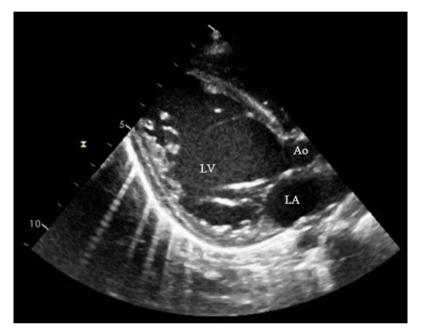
Parasternal long-axis view showing a dilated left ventricle.
